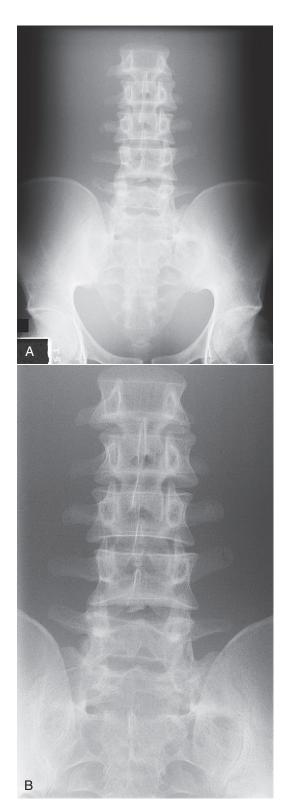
The recommended technique for lumbar spine radiography calls for collimation of the beam to the vertebral column. The full-field technique results in reduced image contrast. A, Full-field technique. B, Preferred collimated technique. (Courtesy Mike Enriquez, Merced Community College.)
